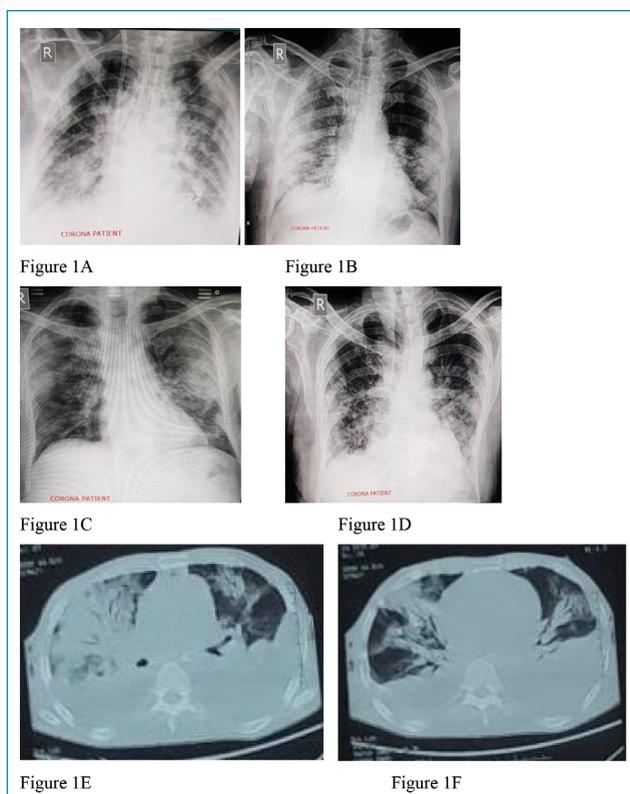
Representative radiographs: (A) honeycomb appearance (ARDS), (B) bronchopneumonia, (C) hyperinflation with consolidation, and (D) hyperemia with basal consolidation; and the computed tomography scan images at axial view showing (E) consolidation with air bronchogram and (F) fibrotic band and pneumonic patches.
